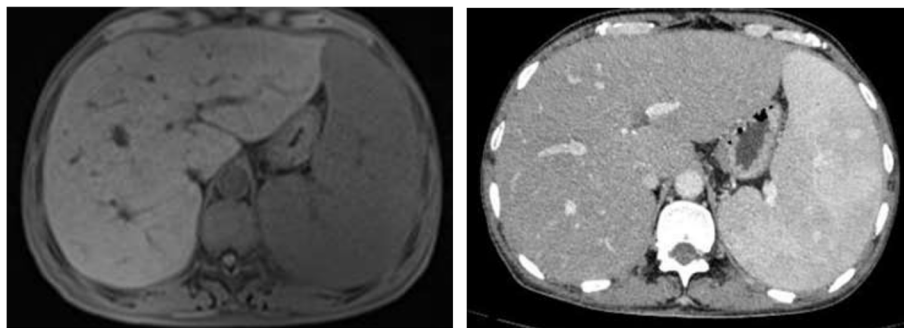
Contrast-enhanced MRI +DWI and Contrast-enhanced CT scan of the abdomen. Left panel: Abdominal magnetic resonance imaging (MRI) at July 2022; Right panel: Abdominal contrast enhanced CT scan at February 2023
